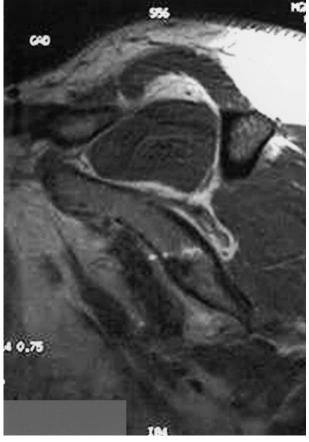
MRI showing a subscapularis rupture associated with advanced fatty degeneration of the subscapularis muscle (parasagital plane medial from the coracoid).
